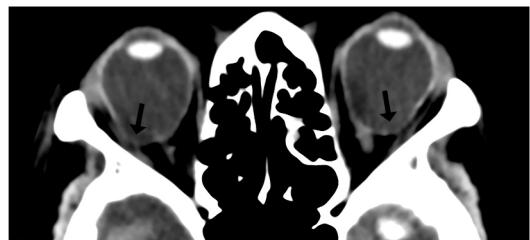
Unenhanced CT orbits in a patient with myopia showing bilateral posterior staphylomas with elongated globes, focal ectatic appearance of the posterior globe with no scleral defect (*black arrows*).
